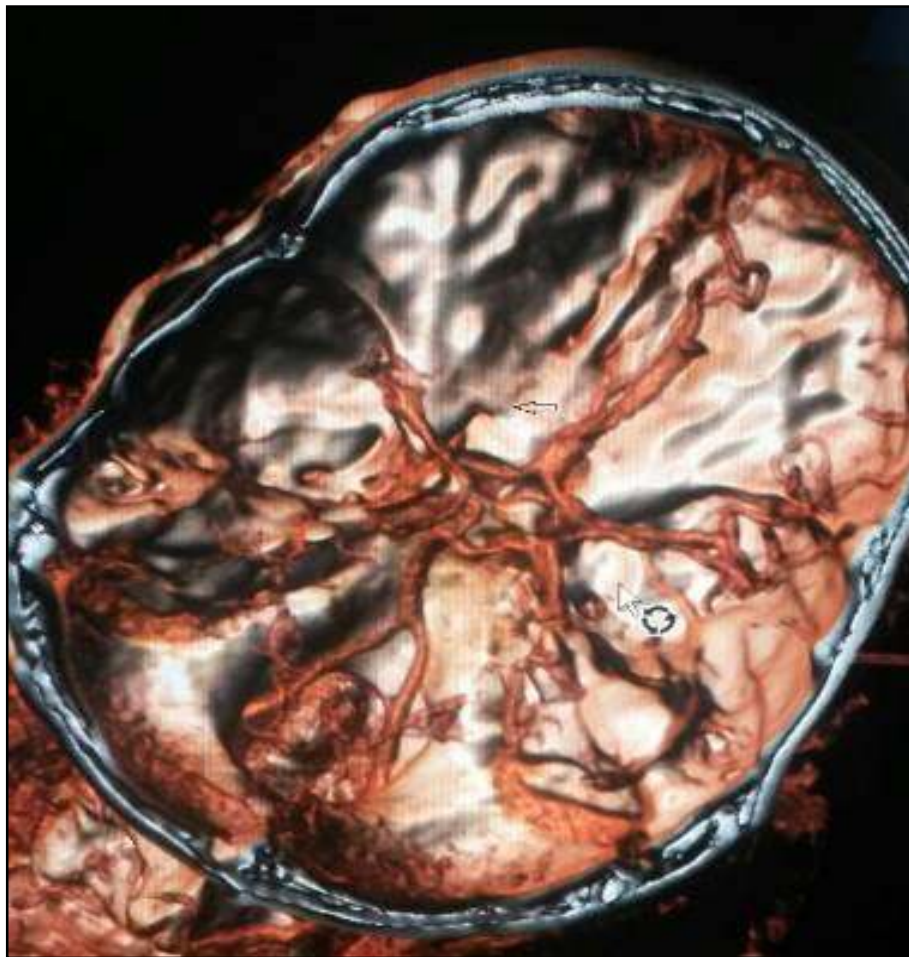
Brain 3D-CT angiography shows complete occlusion of left medium cerebral artery (arrow)
